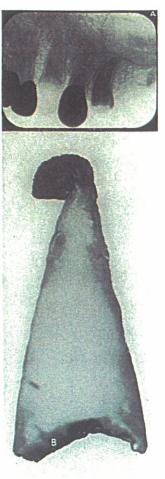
A, ROENTGENOGRAPHIC VIEW OF THE ROOT AND APICAL AREA OF A CUSPID; B, AN ENLARGEMENT OF THE ROOT AND GRANULOMA REMOVED FROM THIS AREA.
